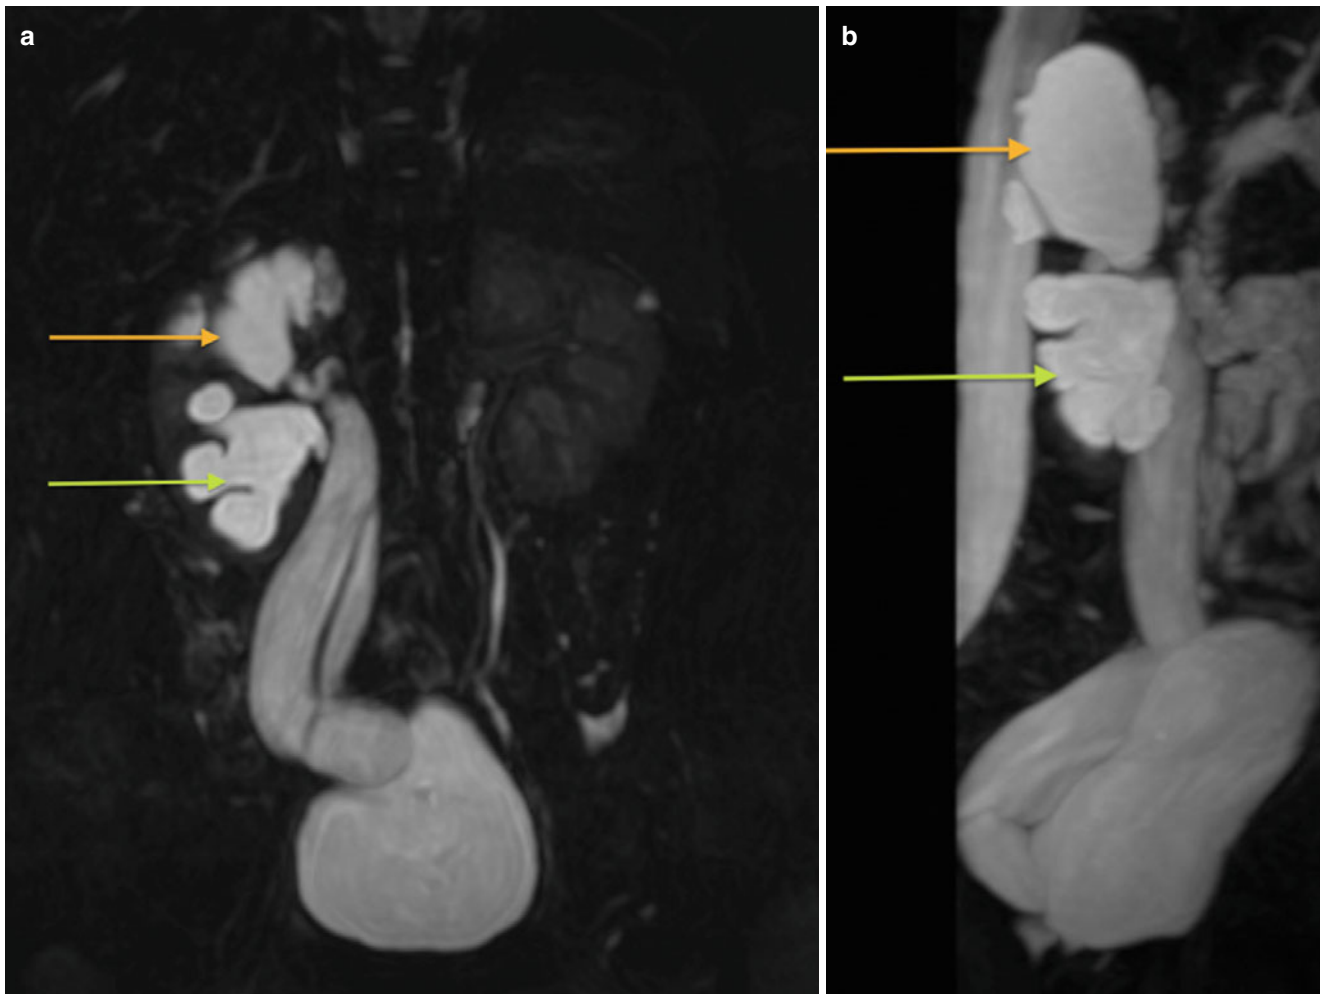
Congenital duplicated renal collecting system with obstruction. Coronal (a) and sagittal (b) heavily T2-weighted images from an MR urogram demonstrate a right duplex collecting system with obstruction of the upper pole collecting moiety (orange arrow) and a
